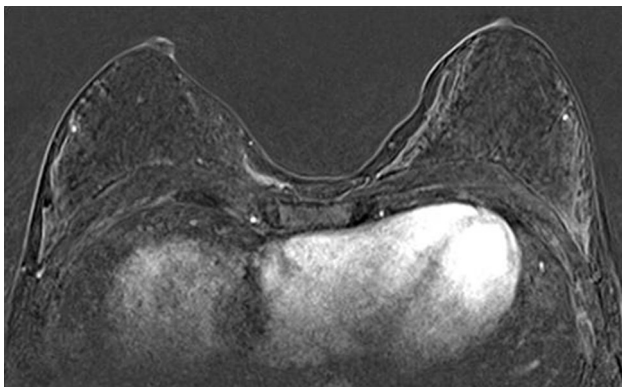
Axial contrast-enhanced T1-weighted fat-suppressed subtraction MR image demonstrating a peripheral “picture framing” BPE pattern
